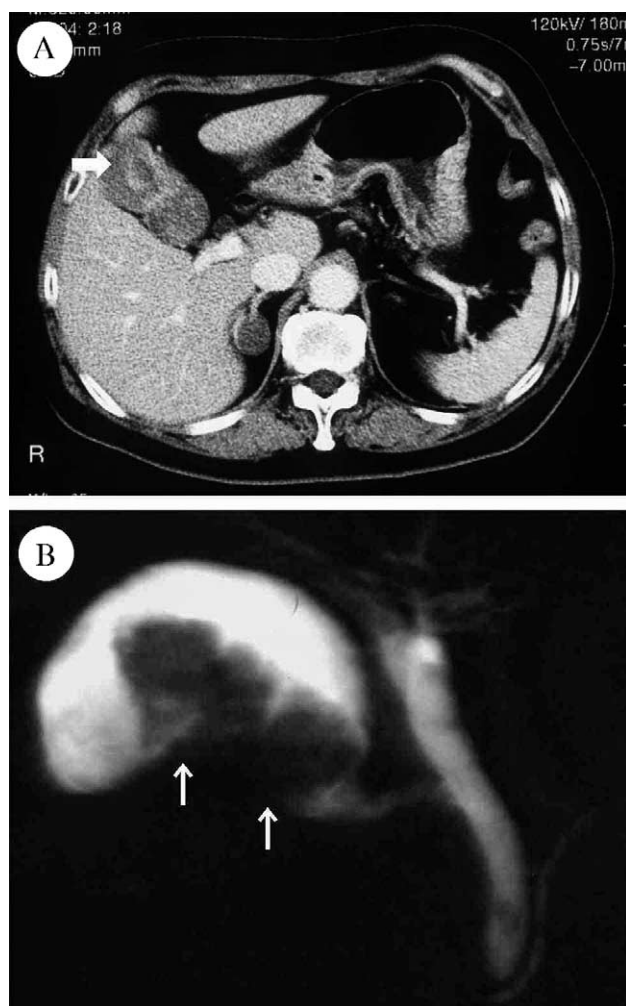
(A) CT of the abdomen and (B) magnetic resonance cholangiopancreatography (MRCP) revealed the presence of a gallbladder tumor (arrows).
